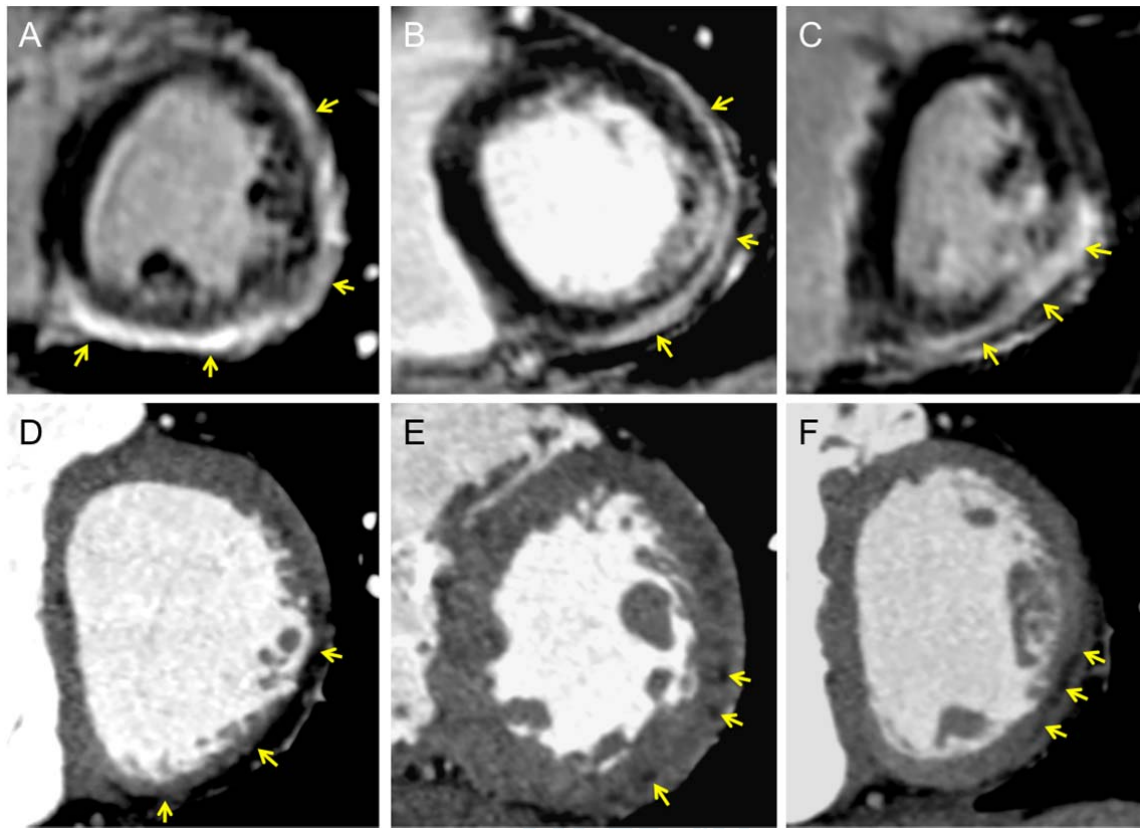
examples of left-sided ARVC substrate on imaging. Top row: late gadolinium-enhanced CMR shows sub-epicardial enhancement consistent with fibrosis on inferior and lateral LV wall in 3 patients (yellow arrows in A, B, and C). Bottom row: iodine-enhanced cardiac-gated MDCT shows intra-myocardial hypo-attenuation consistent with fatty replacement in 3 patients. All patients had a definite ARVC diagnosis based on Task Force criteria. ARVC: arrhythmogenic right ventricular cardiomyopathy; CMR: cardiac magnetic resonance; LV: left ventricle; MDCT: multi-detector computed tomography.
